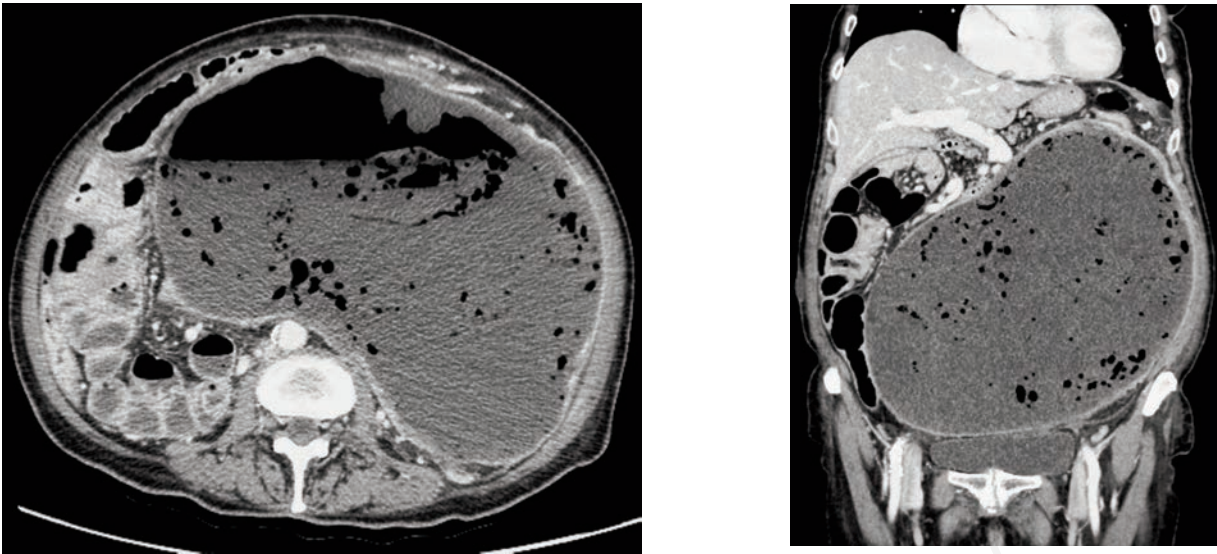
Contrast-enhanced CT. (A) The gas-fluid collection shows a thin peripheral rim; (B) Coronal reformation. CT scans did not demonstrated an intraperitoneal fluid collection (not shown).
